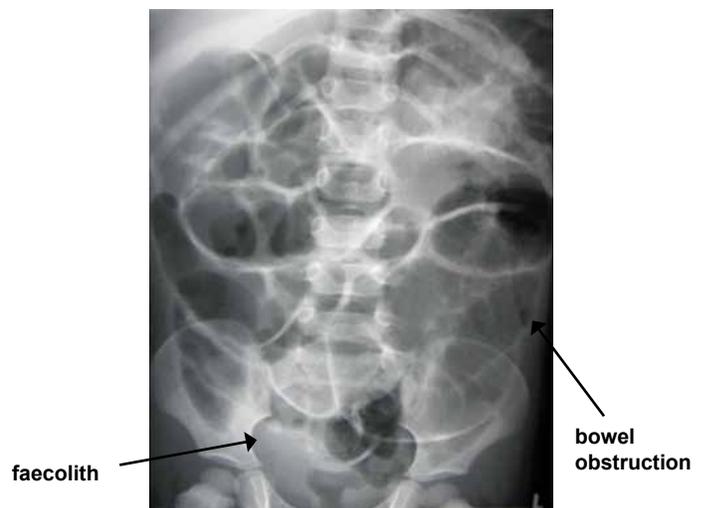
Abdominal radiograph showing a faecolith.
